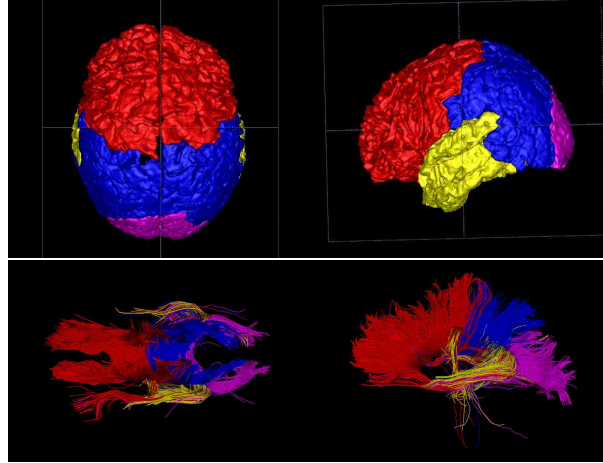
Examples of warped labeled atlas in the space of T1-weighted image (top row) and labeled fibers (bottom row). The left ones are axial view, and the right ones are sagittal view. The colors are: red for frontal lobe, blue for parietal lobe, yellow for temporal lobe and purple for occipital lobe.)
